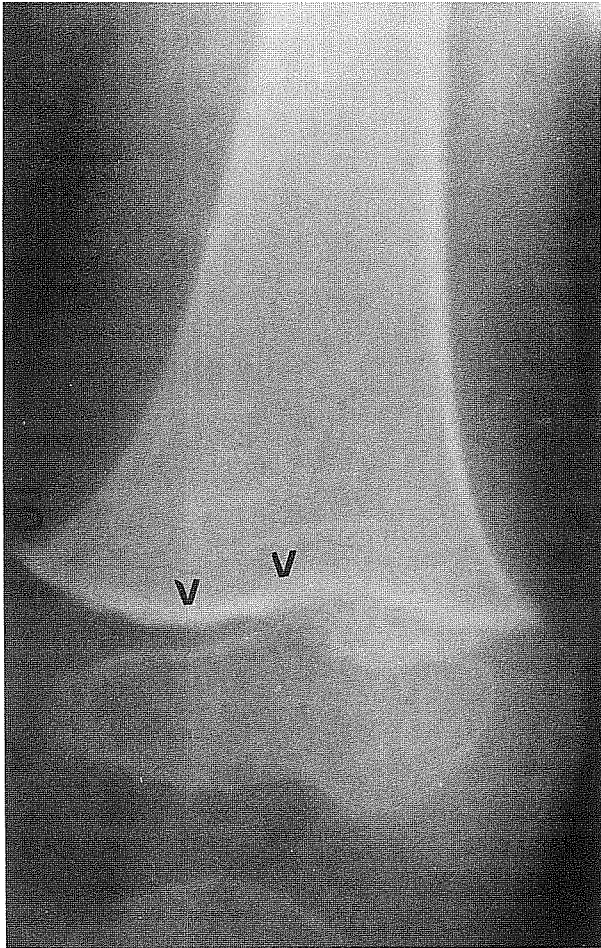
X-ray of the left femur shows Pelkan's spur (arrow) and a radiolucent zone-atrophic scurvy line on the diaphyseal side of the Frankel's line (arrowheads).
